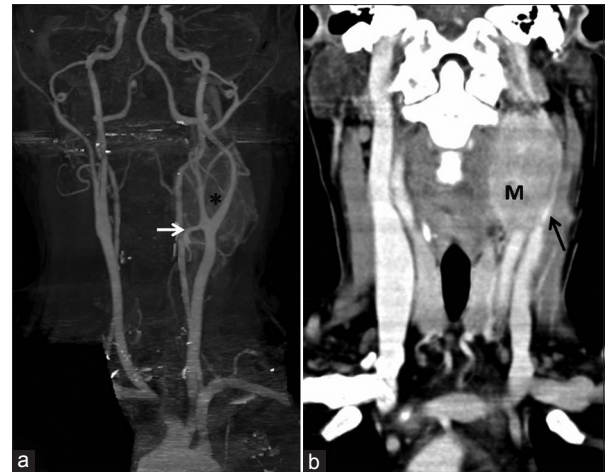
Computed tomography angiography (CTA) carotids (a) 3D: carotid body tumor with splaying of the carotid bifurcation (*). Note: Hypertrophied left descending pharyngeal artery (arrow). (b) Coronal reformats: Significant mass effect on the left internal jugular vein which appears markedly compressed
